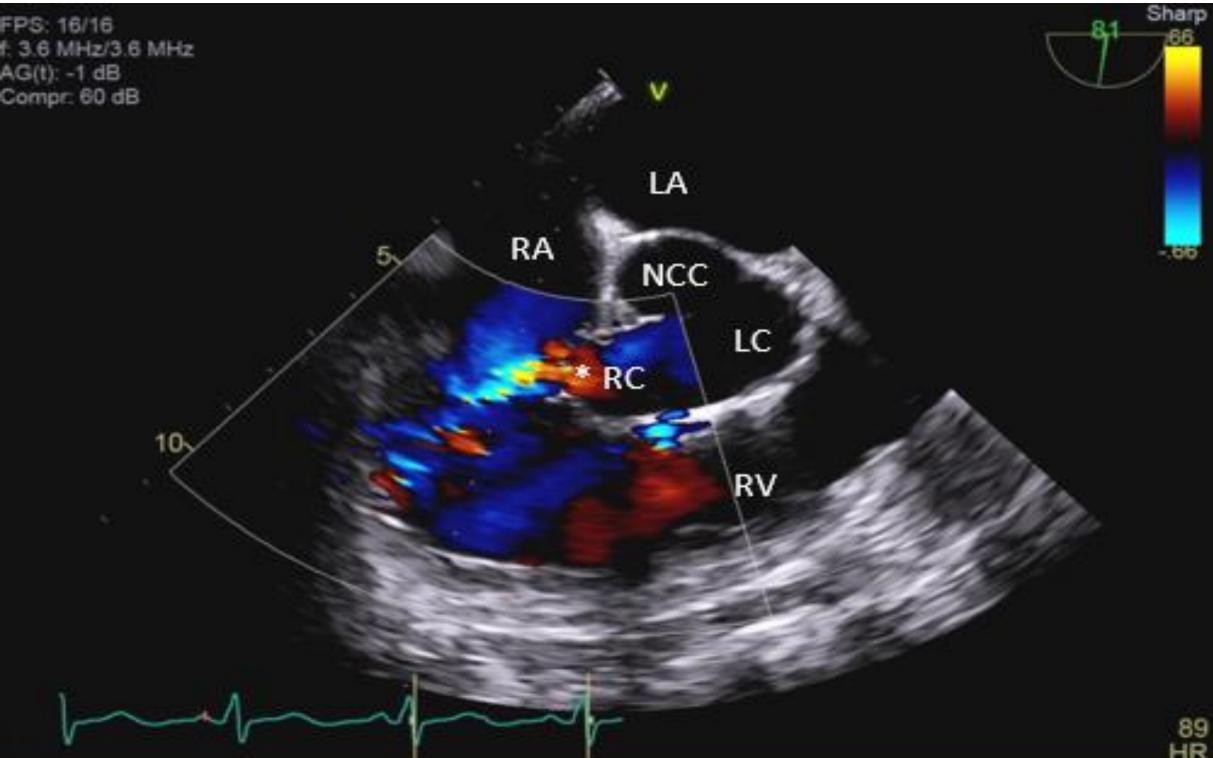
Transesophageal echocardiography (TEE) short axis view with color Doppler showing a jet hitting right side of the heart continuously during both diastole and systole
